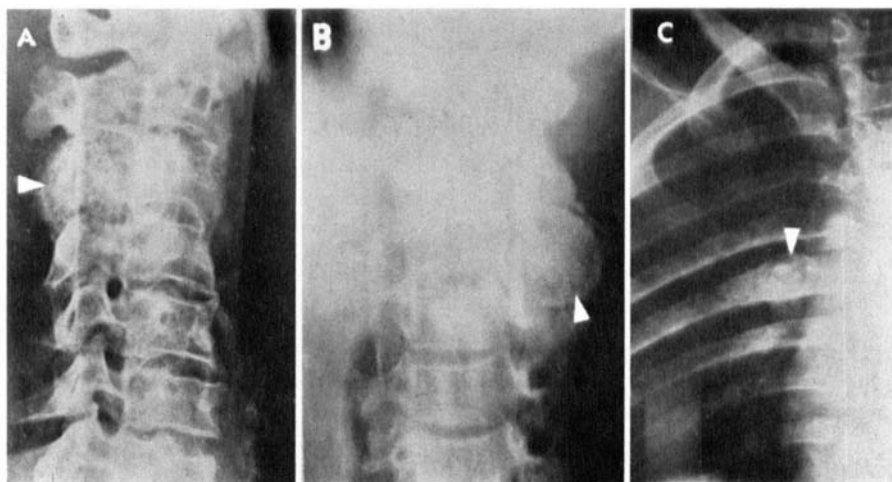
A, B. Case No. 14874, 14-year-old male. A. Roentgenogram. B. Tomography of an osteoblastoma of the apophysis of the third cervical vertebra. C. Case No. 19780, 11-year-old male, osteoblastoma of the 6th rib. In both cases the lesion is central (medullary) and shows patched central calcification.
